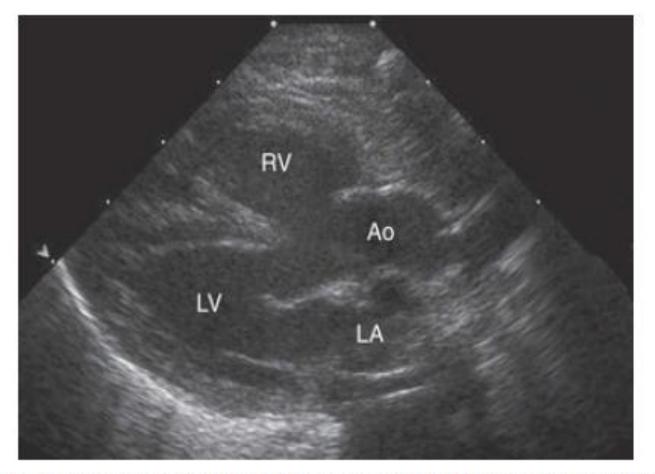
Echocardiogram in patient with tetralogy of Fallot. This parasternal long axis 2D view demonstrates anterior displacement of the outflow ventricular septum that resulted in stenosis of the subpulmonic right ventricular outflow tract, overriding of the aorta, and an associated ventricular septal defect. Ao, Overriding aorta; LA, left atrium; LV, left ventricle; RV, right ventricle.
